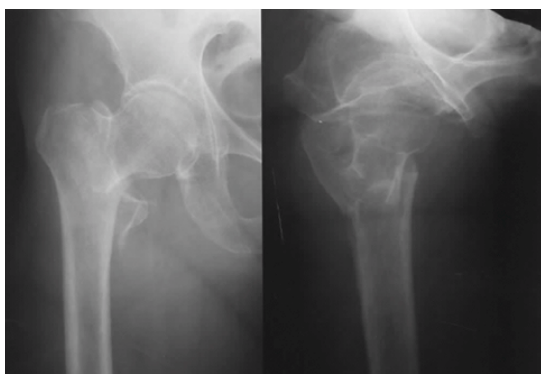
A 74-year-old woman with AO-Muller type A2.1 and Evans-Jensen type IV intertrochanteric fracture. Initial AP and cross-table lateral radiograph shows typical varus displaced fracture pattern and lesser trochanteric fragment.
